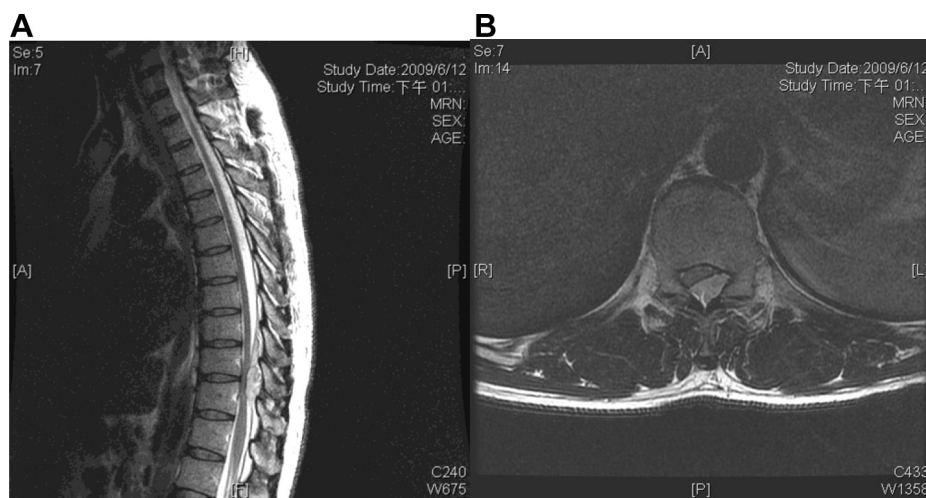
T2-weighted sagittal magnetic resonance imaging of the cervicothoracic spine, showing the spinal cord from T9 to T11 being compressed with a posterior epidural mass lesion: (A) sagittal view; (B) transverse view.
